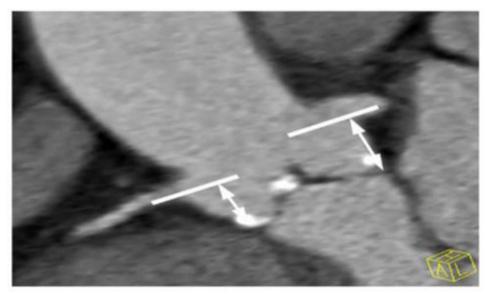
A MDCT image to measure the height of coronary ostia prior to TAVI, Coronary heights > 10 mm are generally considered safe when considering coronary obstruction. SCCT expert consensus document on computed tomography imaging before transcatheter aortic valve implantation (TAVI)/transcatheter aortic valve replacement (TAVR): J. Cardiovasc. Comput. Tomogr., 6 (6) (2012), pp. 366-380 [32].
